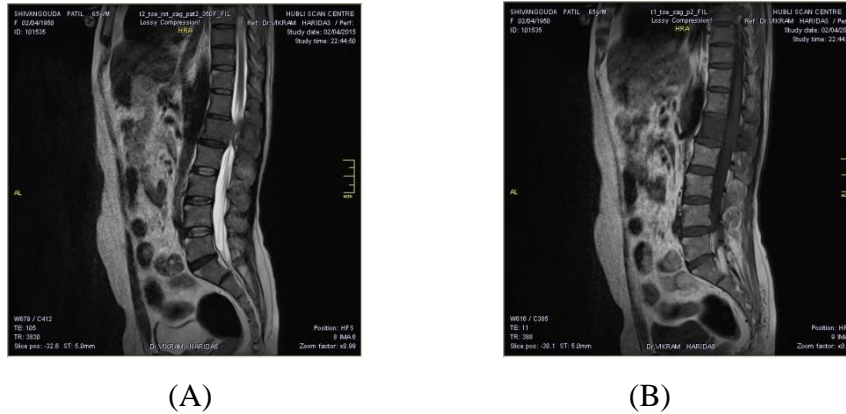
(A), (B): Sagittal T1 and T2W MRI images show abnormal altered marrow signal in L1 vertebral body. Soft tissue lesion is seen in posterior epidural space at this level compressing thecal sac and nerve roots.
